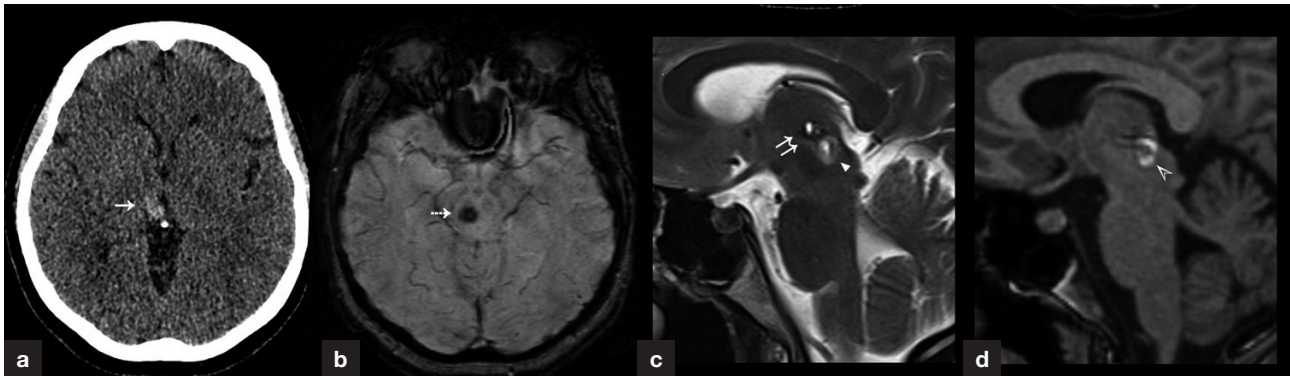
Imaging features of a symptomatic right thalamo-mesencephalic cavernous malformation. a. Axial computed tomography demonstrates a focal area of hyperdensity in the medial right thalamus (single arrow), with mild mass effect on the adjacent third ventricle but no hydrocephalus. On (b) axial susceptibility-weighted, (c) sagittal T2-weighted and (d) sagittal T1-weighted magnetic resonance images, this region corresponds to a bilobed, mixed intensity lesion in the right medial thalamus and midbrain, with blooming hypointensity on susceptibility-weighted imaging (dashed arrow in b) and a haemosiderin rim (double arrows in c). Magnetic resonance imaging is the most sensitive and specific investigation for cavernomas.
